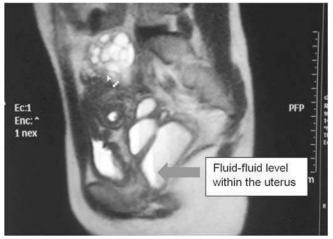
MRI: A thickened endometrium with fluid-fluid levels within.
